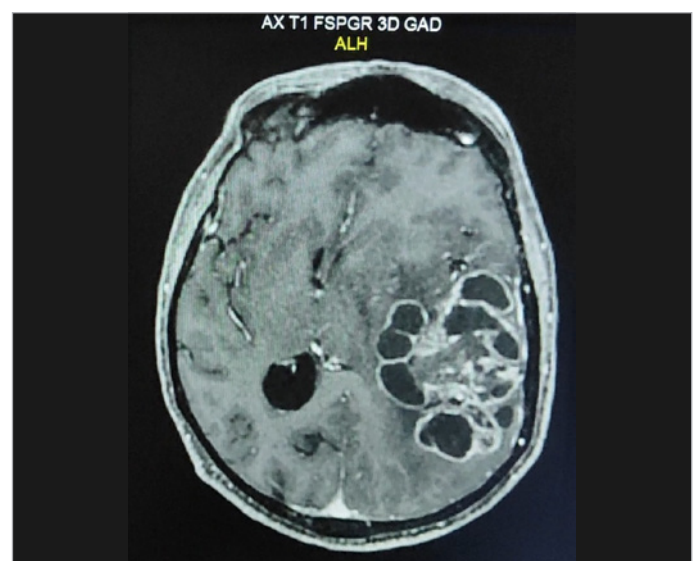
Axial view of contrast-enhanced MRI showing lesion in the left temporoparietal region. In this figure we can ser the intense rim enhancement with central clearing typical from glioblastomas.
